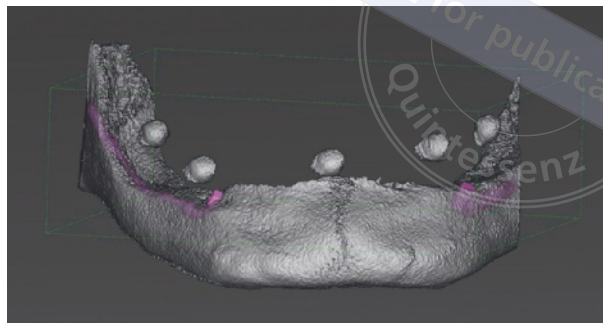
CBCT with the mandibular complete denture inserted. Only the reference bodies are visible.
